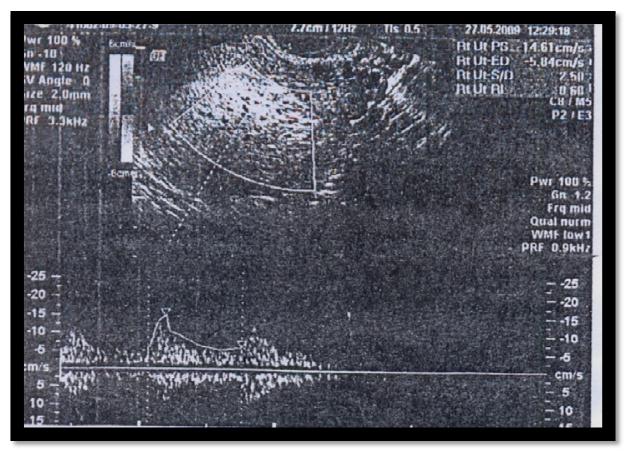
b) Doppler evaluation of first trimester pregnancy above patient
